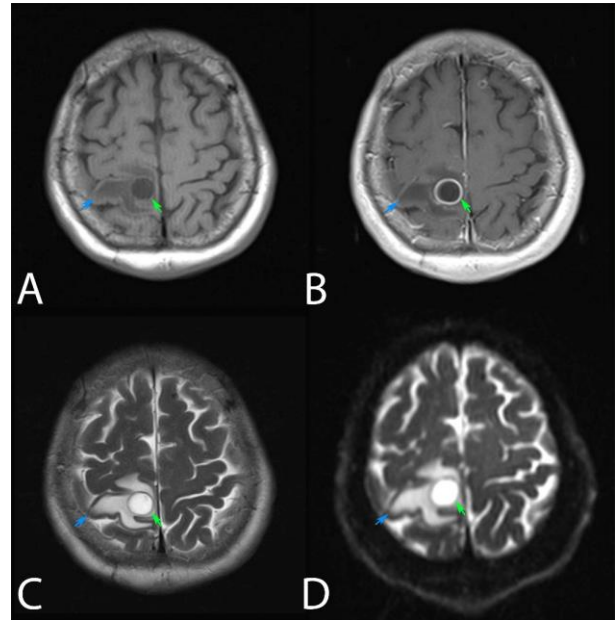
Brain MRI with contrast showing focal cortico-subcortical lesion in the right parietal region (green arrows) (approximately 20x16 mm) with discretely heterogeneous internal signal, predominantly hypointense in T1 (A), hyperintense in T2 (C), and diffusion-weighted (D), identifying iso-intense eccentric focus in all sequences and capsular-pseudocapsular margin less than 2 mm thick. Capsular-septal and eccentric focus enhancement, especially in postcontrast sequences (B), associated perilesional vasogenic edema conditioning discrete local mass effect with effacement of adjacent cortical sulci (blue arrows).
